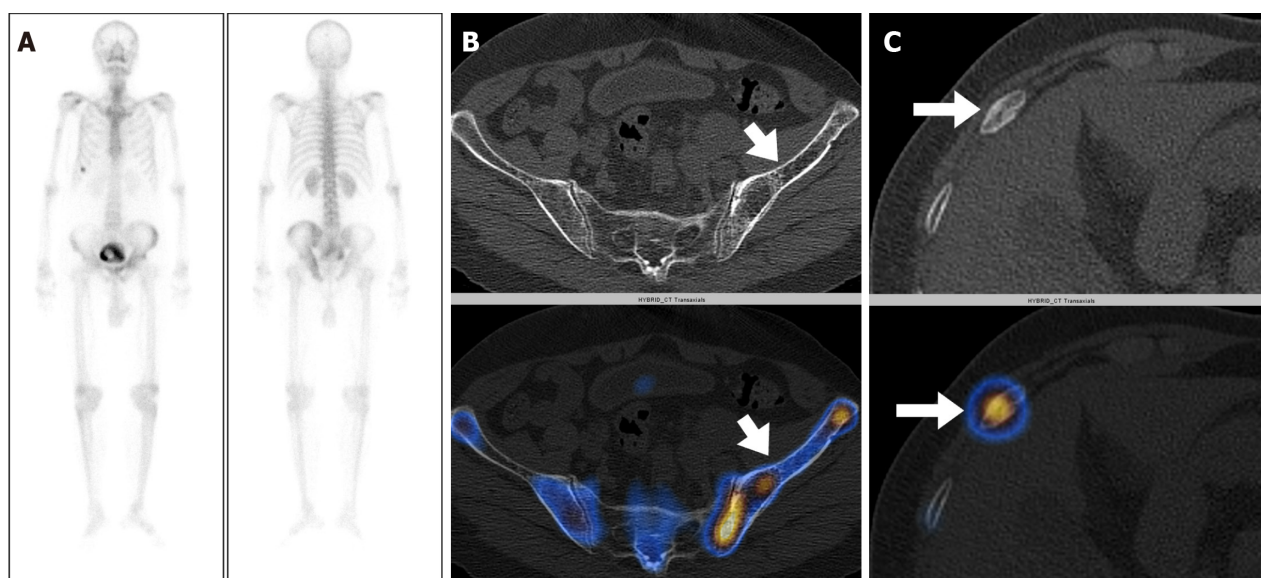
A 77-year-old male with carcinoma of the prostate and a Gleason's Score 8 (4 + 4) and serum prostate-specific antigen level of 100 ng/mL. A: Staging whole body bone scintigraphy show heterogeneously increased tracer uptake involving the left hemipelvis and focal areas of increased tracer uptake involving the right 8th rib raising the suspicion of metastatic disease; B and C: Axial computed tomography (CT) and fused single photon emission computed tomography-CT images localizes the tracer to the left iliac bone with cortical thickening and bony expansion consistent with Paget's disease (arrow in B) and to the right 8th rib anteriorly with a fracture line (arrow in C).
